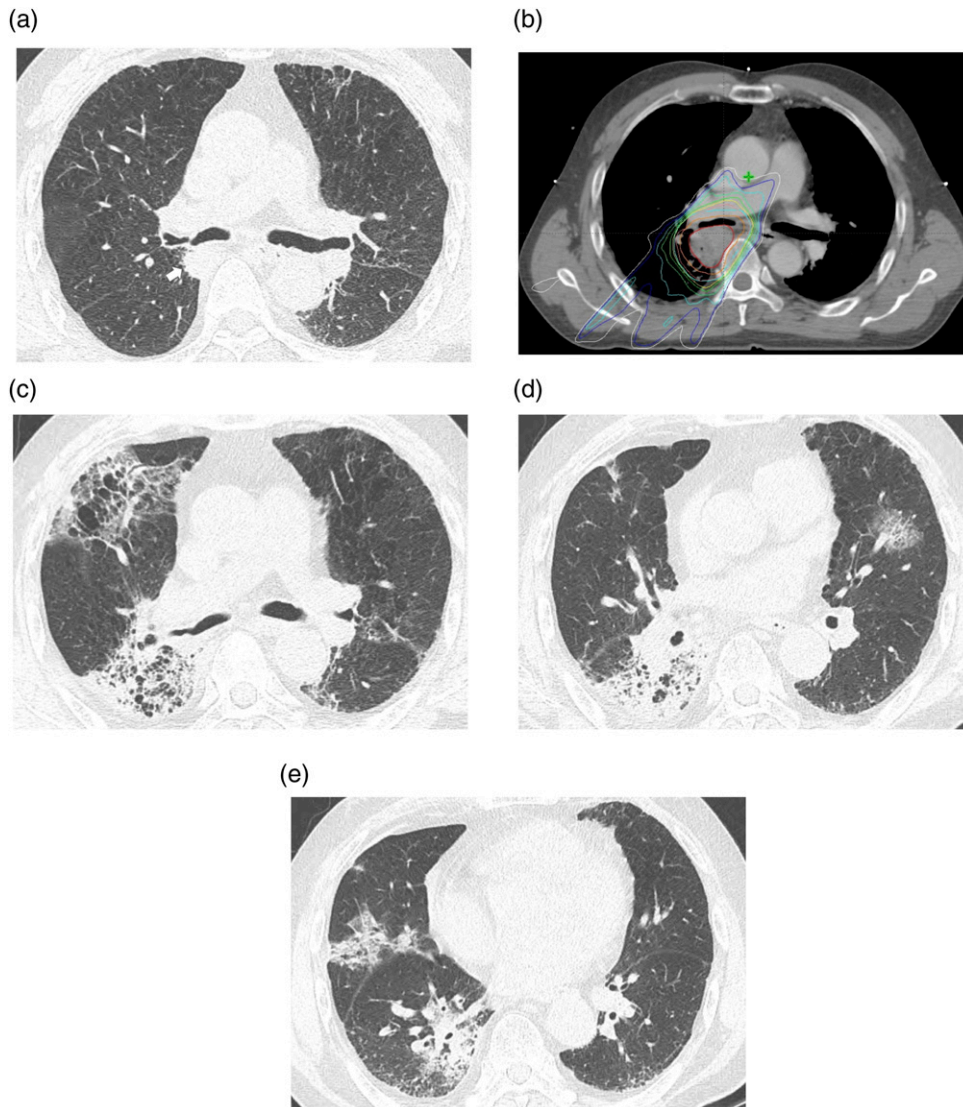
Radiation pneumonitis presenting cryptogenic organizing pneumonia pattern in a 71-year-old male patient who was diagnosed with lung adenocarcinoma. The GTV, RT dose, MLD, and Lung V20 were 39 cm³, 7000 mGy, 1295.9 mGy, and 23.1%. At the clinical follow up, he had symptoms of dyspnea (CTCAE grade 3). (a) Pre-RT CT shows the primary lung cancer (arrow) in the prevertebral area of the right lower lobe and underlying diffuse emphysema in both lungs. (b) Isodose multiplanar image for IMRT (c)–(e) Chest CT scans 5 months after RT show that the primary lesion has decreased in size and there is development of multifocal peribronchial and subpleural GGO and consolidation in both lungs.
